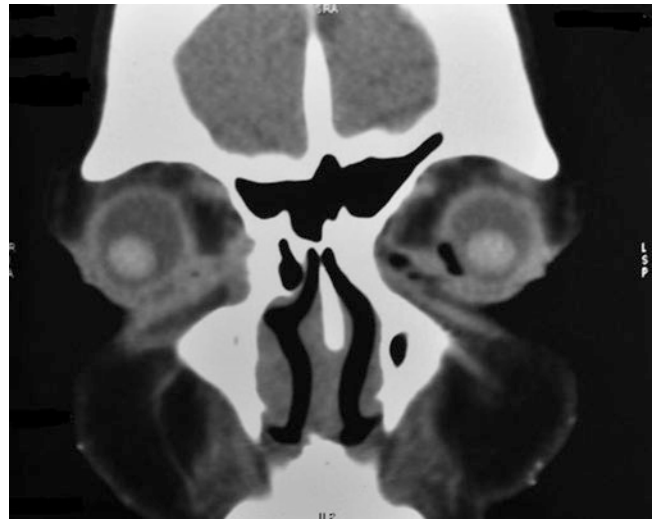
Coronal CT of a lacrimal sac malignancy with lacrimal crest involvement
